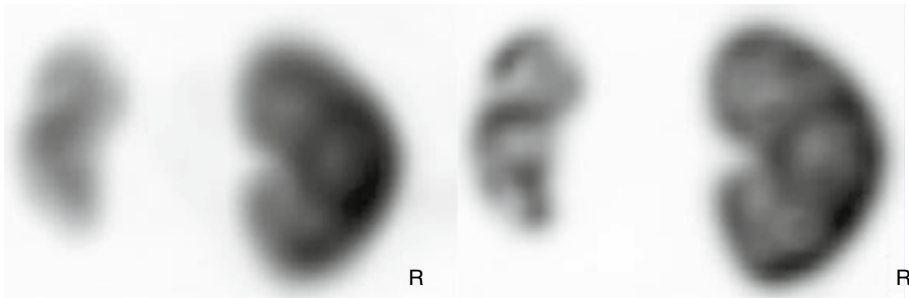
Effect of OSEM 3D and resolution recovery on DMSA SPECT [54]. *Left:* DMSA SPECT reconstructed with Filter Back Projection. *Right:* DMSA SPECT reconstructed with OSEM 3D with resolution recovery
